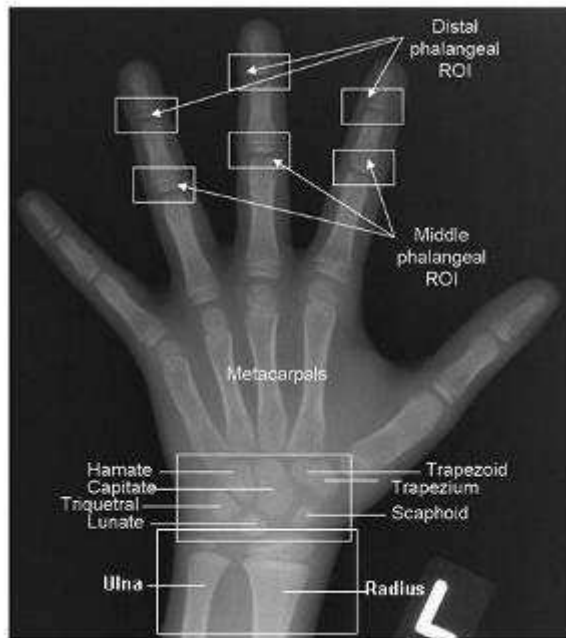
A hand and wrist radiograph with phalanges, carpal bones, and the wrist joints ROIs.
